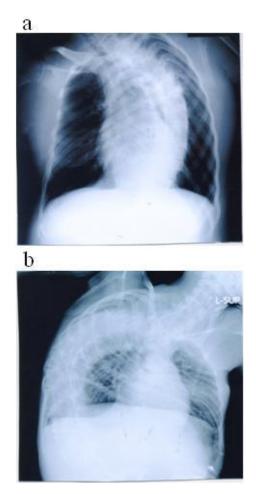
Deformed thorax on chest X-ray. (a) Chest X-ray of Case 1. (b) Chest X-ray of Case 2.
